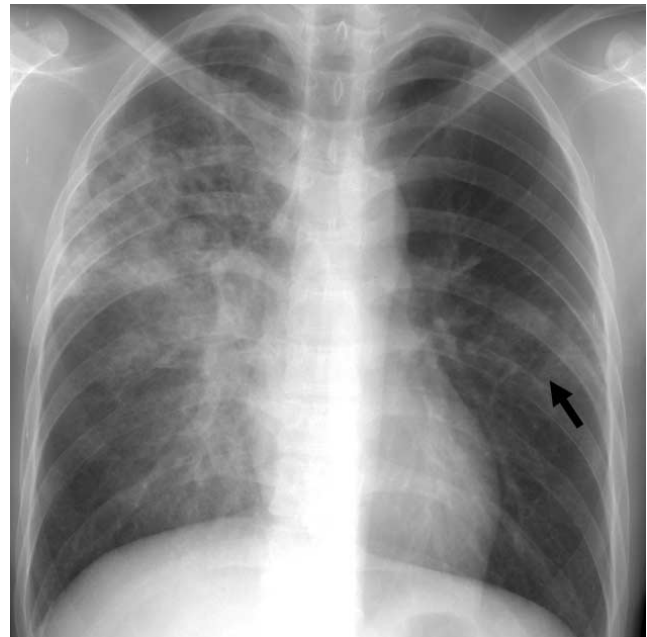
Findings for extensively drug-resistant pulmonary tuberculosis in 29-year-old man. Posterior-anterior chest radiograph shows nodules, consolidation containing cavities and ground-glass opacity in right lung and reticulo-nodular lesions (arrow) in left middle lung zone.
